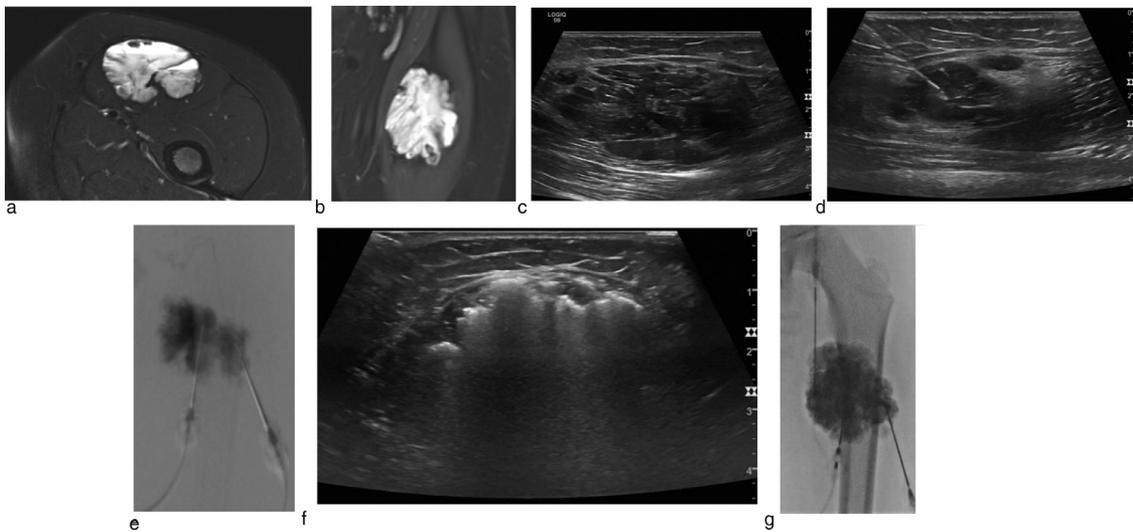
5-year-old female with intramuscular VM of the left thigh. Sclerotherapy was performed with STS foam. Axial STIR (a) and coronal FSEIR (b) magnetic resonance images of the left thigh show increased signal of the intramuscular VM. Note the fluid levels on the axial image as well as scattered hypointense foci compatible with phleboliths. Grayscale ultrasound demonstrates dilated venous channels within the malformation (c) and ultrasound-guided placement of a 21-gauge EchoTip needle into one of these channels (d). Intralesional venography via this needle and another needle placed more laterally within the malformation (placement not shown) using negative roadmap fluoroscopy (e) shows opacification of the malformation without evidence of extravasation or visualization of large draining veins. Postsclerotherapy grayscale ultrasound shows echogenic foam distributed throughout the malformation (f). Postsclerotherapy spot fluoroscopic image (g) demonstrates contrast opacification of the treated lesion. (Note that a third access into the malformation had been obtained to facilitate treatment of the entire lesion.)
